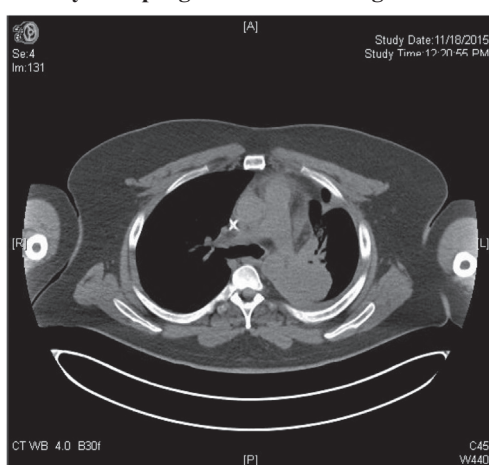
CT scans demonstrating a partial response during therapy with nivolumab. Baseline: prior to nivolumab start Day 47: a partial response following 4 cycles of nivolumab Day 246: progression of left lung mass.
